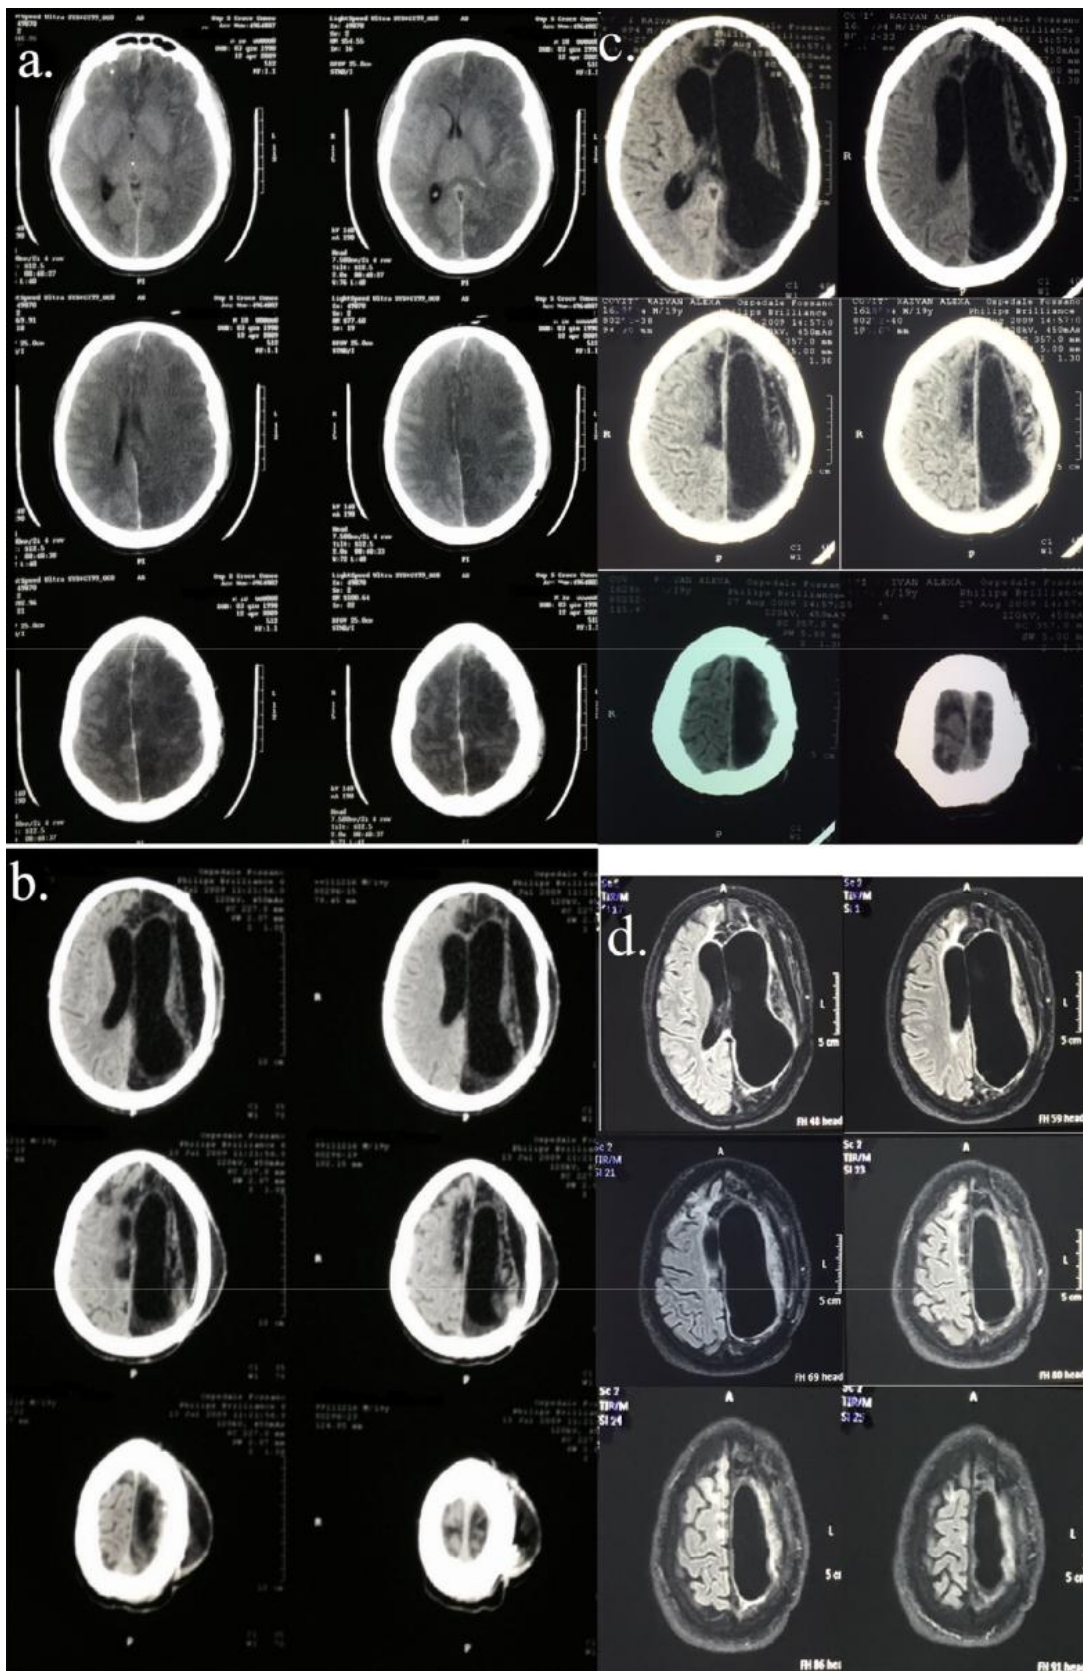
Axial and sagittal scans showing the marked progression of ventricular dilation in A.C.: (a) first CT scan (April 2009) on the day of injury; (b) second CT scan (July 2009); (c) third CT scan (August 2009); (d) MRI scan (October 2013). Images are in radiological perspective with left on the viewer's right.
